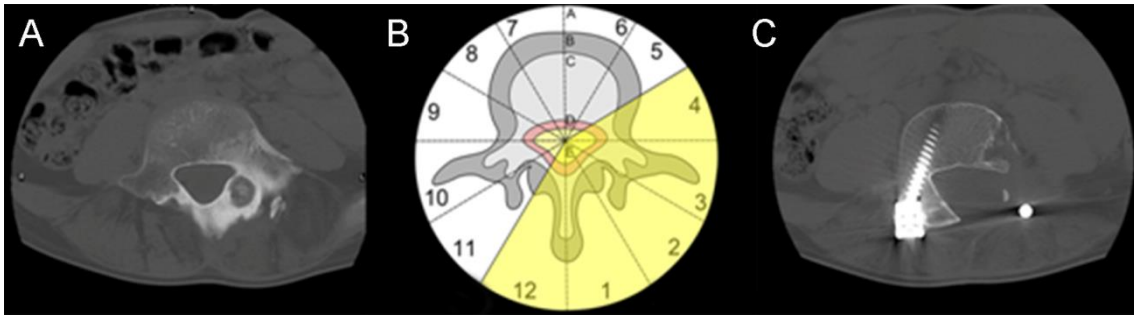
En bloc resection by posterior approach: A. axial CT image of an L1 osteoid osteoma, B. the planning phase of the surgery according to the Weinstein-Boriani-Biagini staging system, C. postoperative axial CT image of the L1 vertebrae.*
